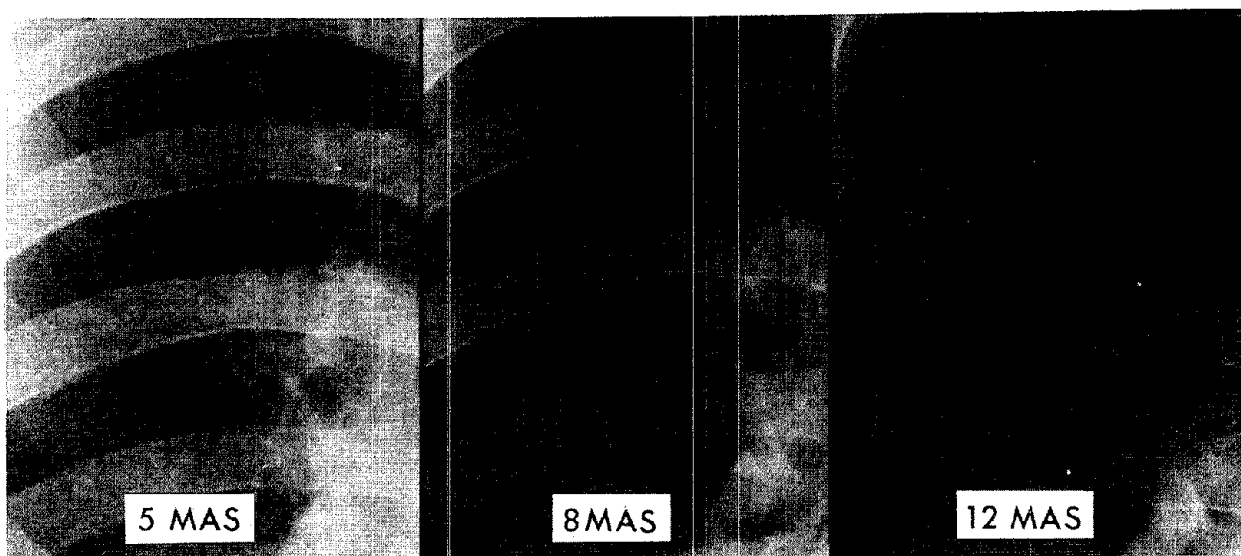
Overexposure of the film causes the disease process to disappear. There are small rounded opacities of the "P" variety. They are the most difficult to detect on the radiograph and require optimum film quality. Overexposure results in inaccurate interpretation.
